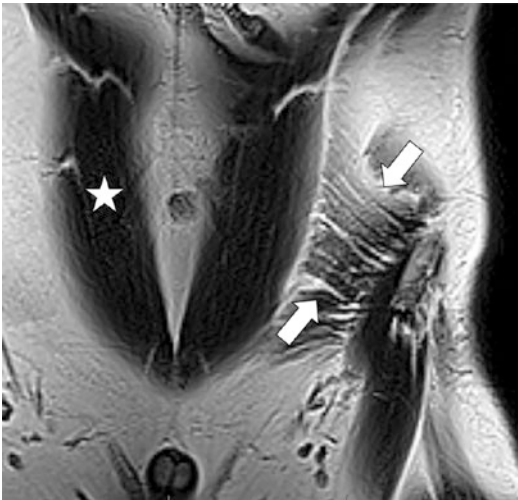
Coronal T2-weighted image through the ventral abdominal wall demonstrates the internal oblique (arrows) and rectus abdominis musculature (star)
